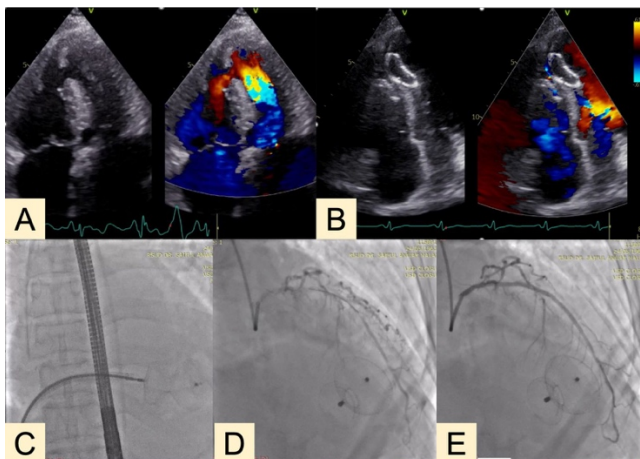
(A) Echocardiography showed apical VSR. (B) Post-transcatheter VSR closure showed occluder in situ. (C) Fluoroscopy during transcatheter VSR closure. (D) PCI procedure on critical stenosis at LAD. (E) Post PCI showed stenotic lesions improved.
